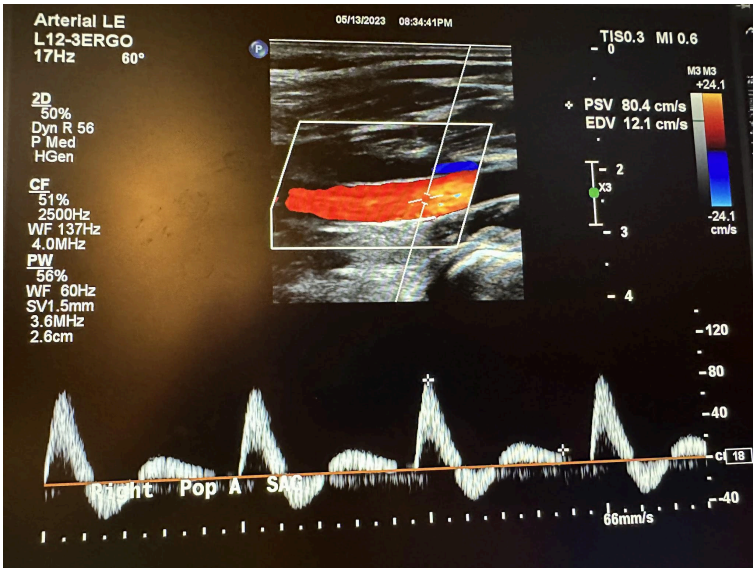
Sagittal image of the right popliteal artery with color Doppler and waveform analysis.
